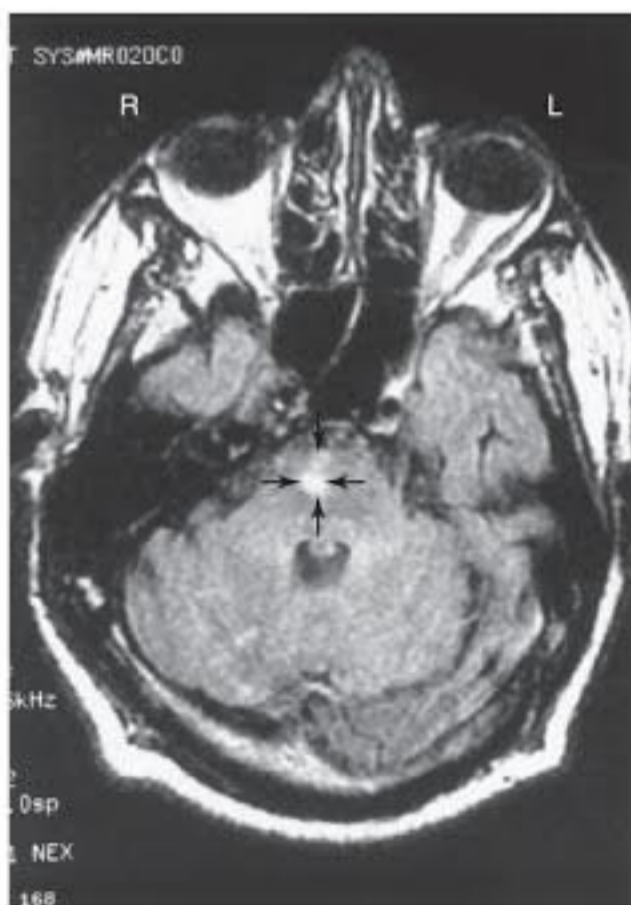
Magnetic resonance image of the brainstem and cerebellum without gadolinium demonstrates an acute right pontine infarct. The infarct appears white and is indicated by arrows.
